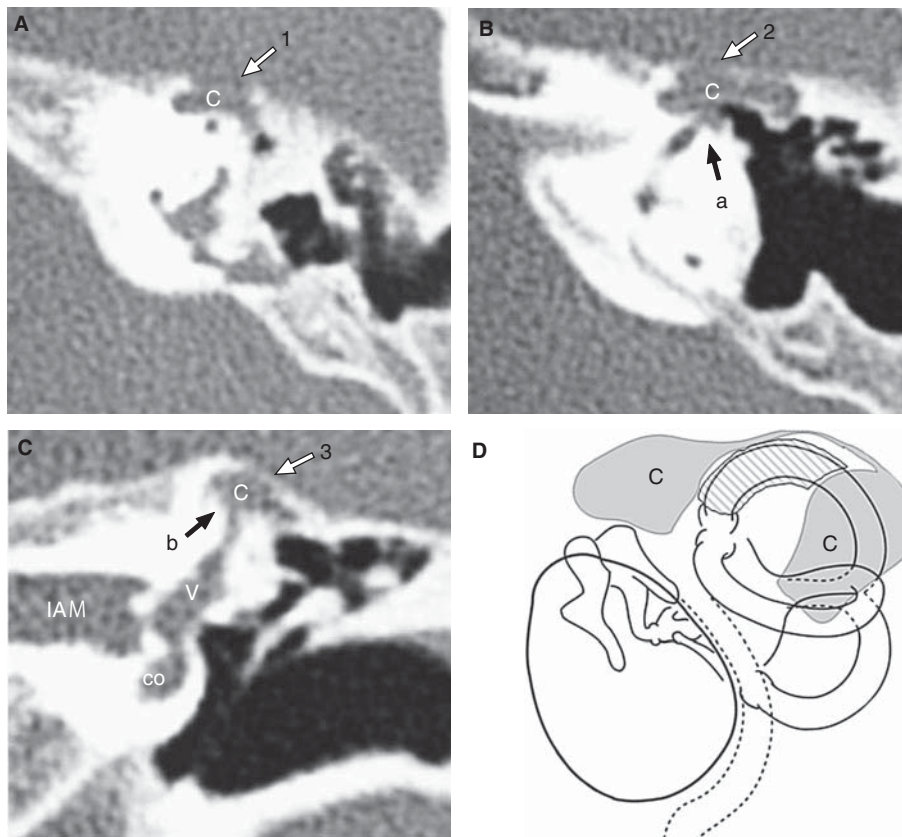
Case 2. (A–C) CT scans (A, B, axial; C, coronal) of the left ear showing soft tissue density (cholesteatoma) (white arrows 1, 2, 3) extending to the medial portion of the superior semicircular canal (SSCC), and apparent fistula involving the SSCC (black arrows a and b). (D) Scheme of extension of the cholesteatoma based on the operation findings. Cholesteatoma extended medial to the SSCC and PSCC. C, cholesteatoma; co, cochlea; IAM, internal auditory meatus; V, vestibule.
